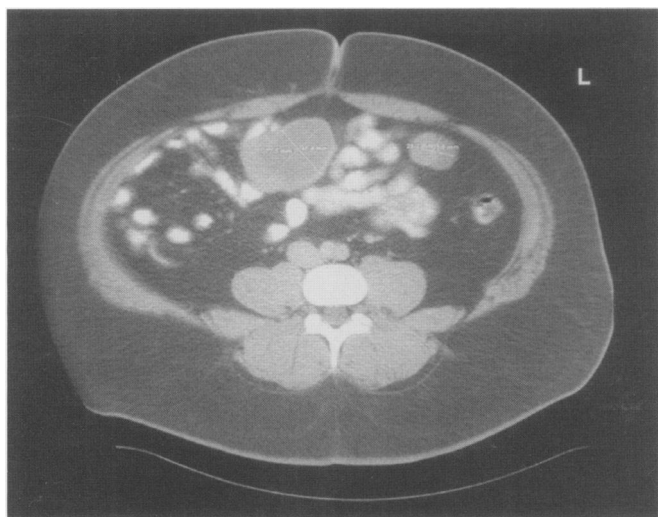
CT scan of abdomen demonstrating two mesenteric cysts.
